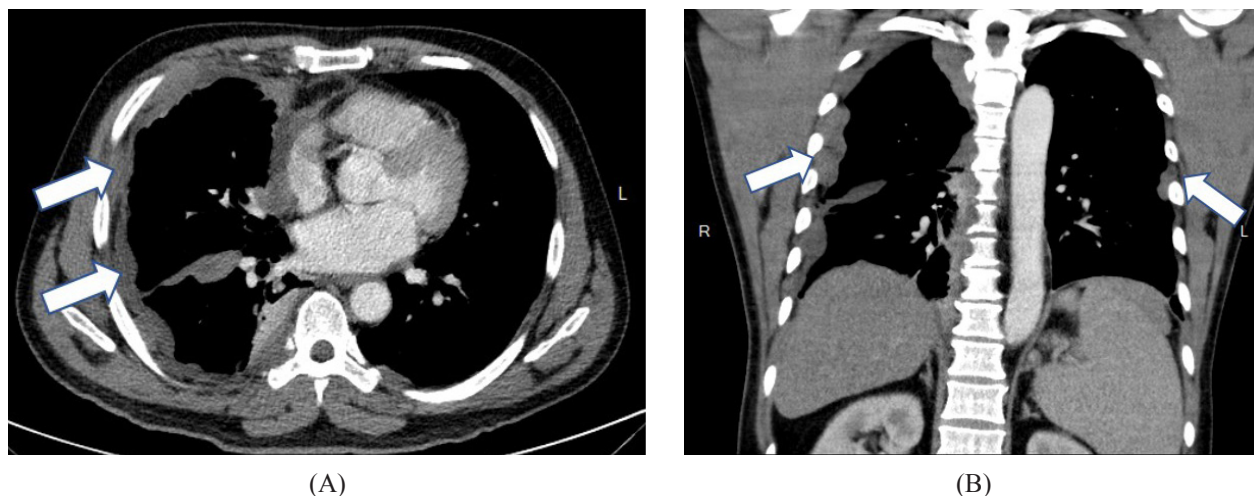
Computed tomography scan shows bilateral loculated pleural effusion (arrows) with right lower lobe atelectasis (A. axial view; B. coronal view).
